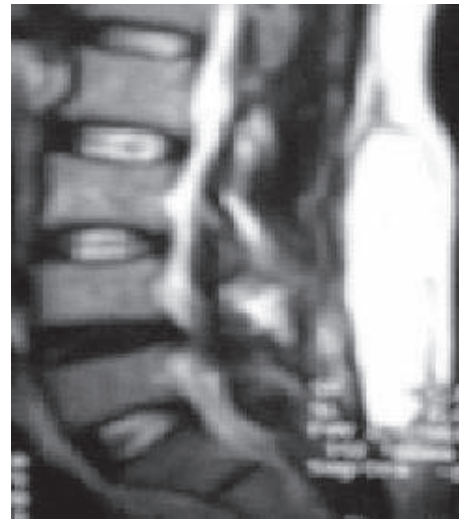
MRI showing haematoma
